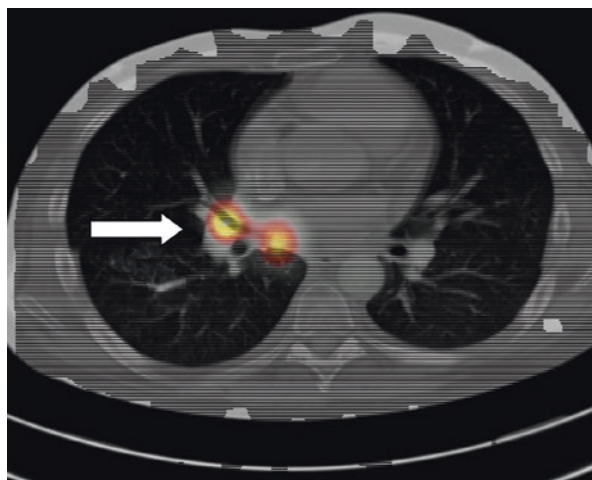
FDG-PET scan: tracer uptake in the dorsal lower and middle lobe and the right hilar region
